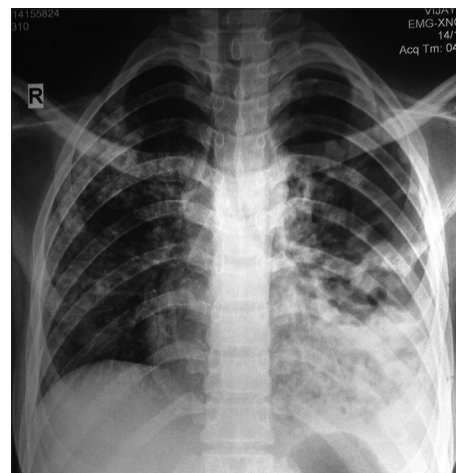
(Case 2) Chest X-ray on admission
